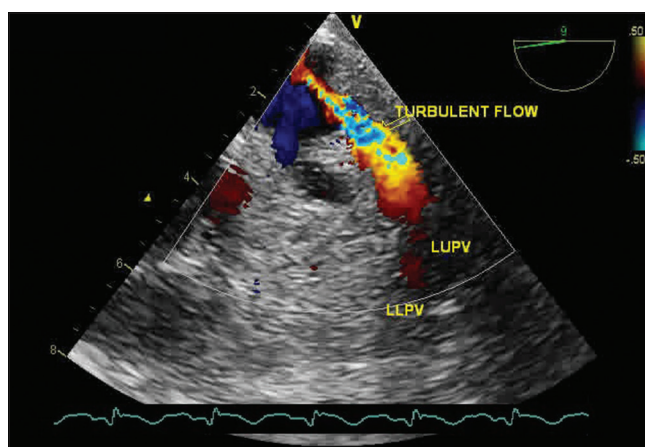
Color Doppler of the left upper pulmonary vein showing turbulence
